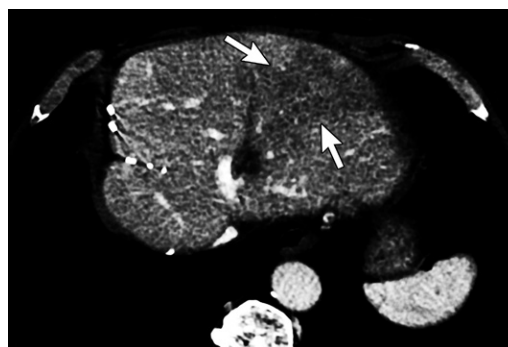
Perivascular edema and inflammation in a 73-year-old man with colorectal liver metastases. Axial portal venous phase MR image obtained after TARE shows ill-defined geographic areas of hypoattenuation with no mass effect (arrows). Note the small blood vessels traversing these areas.
